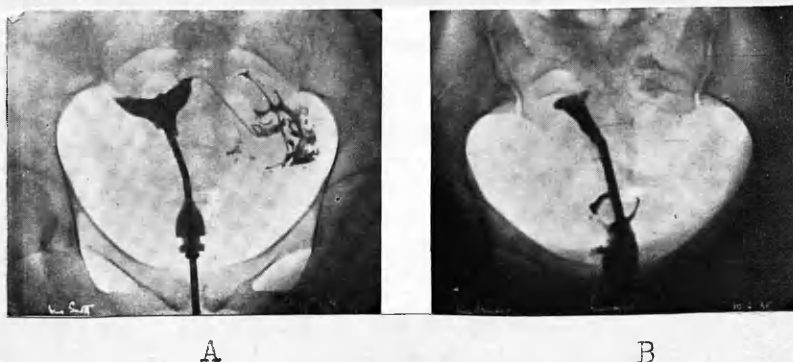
A. Right cornual occlusion, left tubal patency. The right tube does not contain lipiodol, but the left is full and oil has escaped into the peritoneal cavity. B. Tubes blocked at cornua: radiograph 24 hours later showed no lipiodol.
